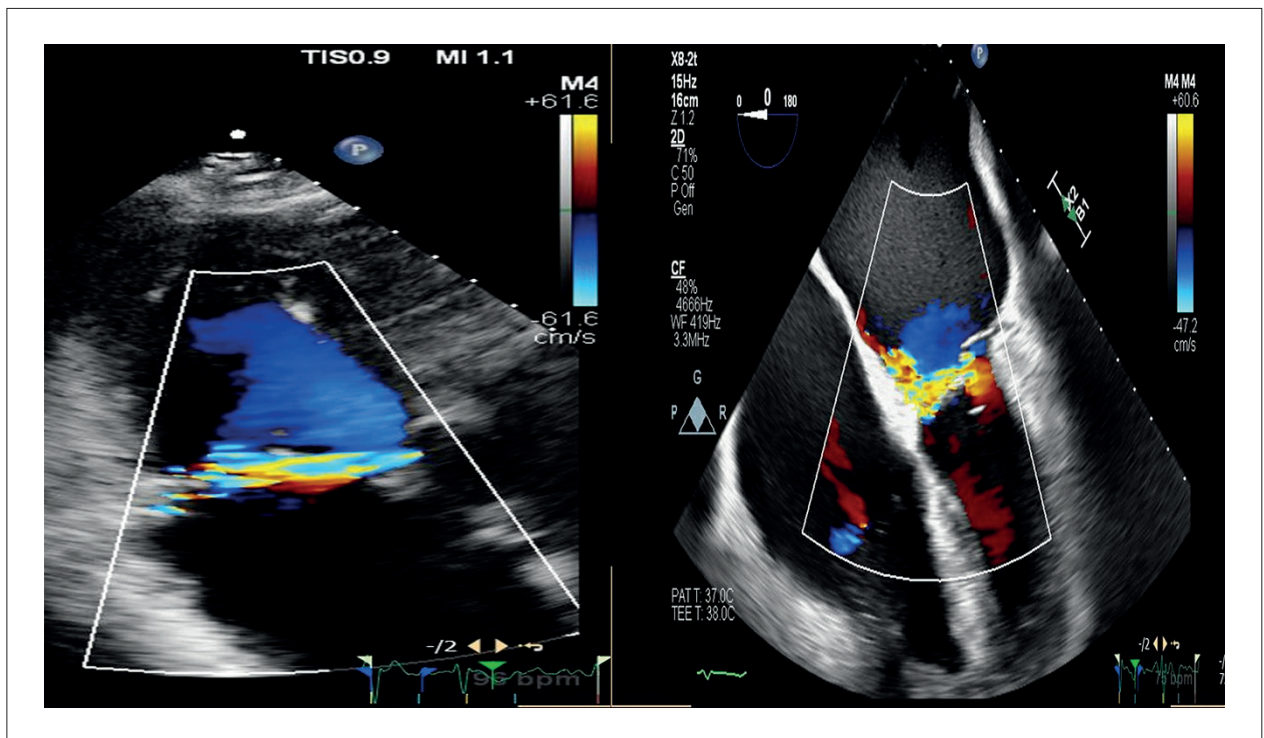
Splay in MR. On the left, transthoracic echocardiography in the apical 3-chamber view shows evidence of splay on color Doppler at the level of the mitral annulus. On the right, transesophageal echocardiography reveals significant MR with a medially directed eccentric jet.
